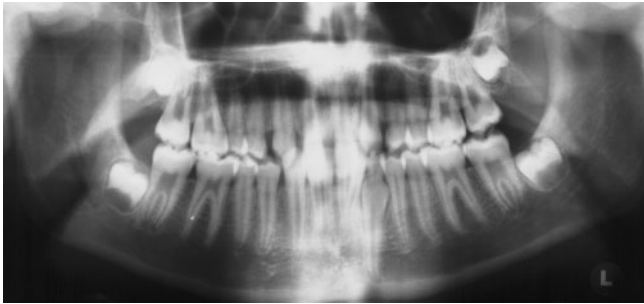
Case report 1: pre-treatment orthopantomogram
